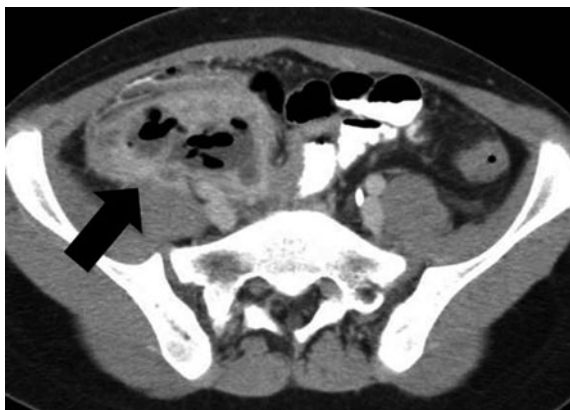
Abscess due to appendicitis in an 11-year-old-female with right lower quadrant pain. Axial contrast-enhanced CT image identifies a right lower quadrant fluid collection with a thick, lobular-enhancing wall and several foci of internal air (*arrow*). No appendix could be seen with CT
